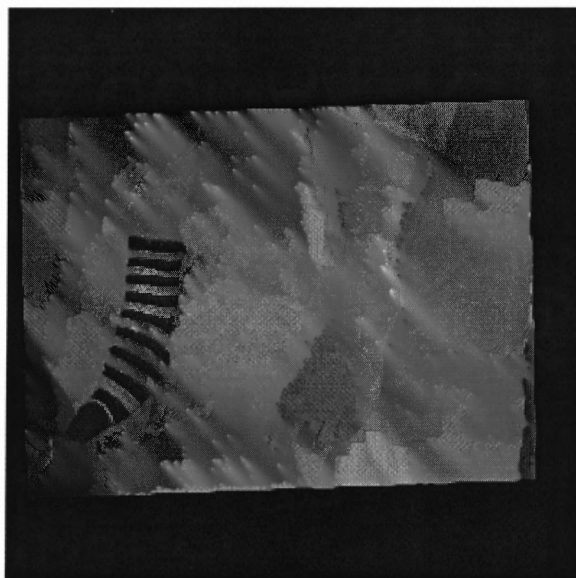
Fused image. The hue in this image contains the scintigraphic intensity. The regions with the least radioactivity are red in hue and increased levels of radioactivity are coded as yellow, green, blue and magenta, respectively.
